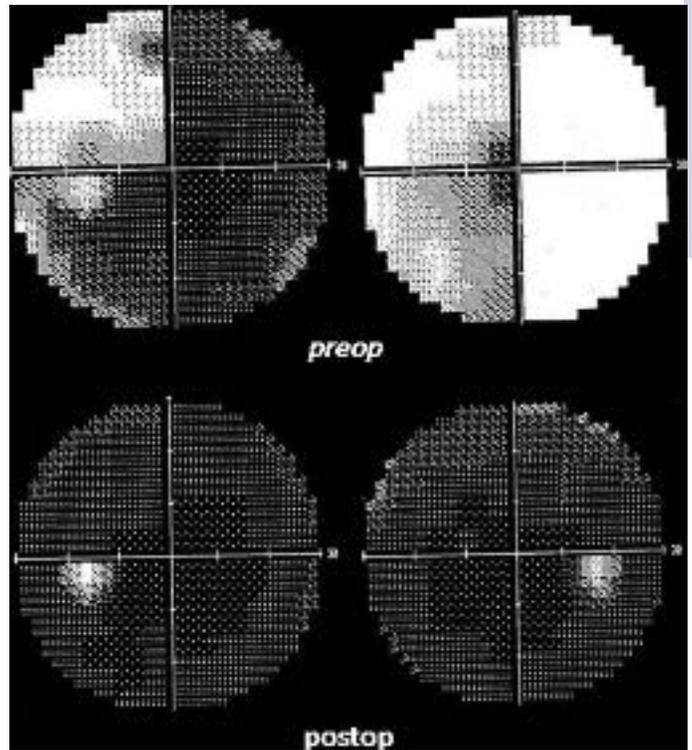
Preoperative (top) and postoperative visual fields in a patient whose magnetic resonance imaging scan is shown in Fig. 21.6. A gratifying recovery of field has occurred. Property of the Department of Neurosurgery, The University of Texas M.D. Anderson Cancer Center. Used with permission.
